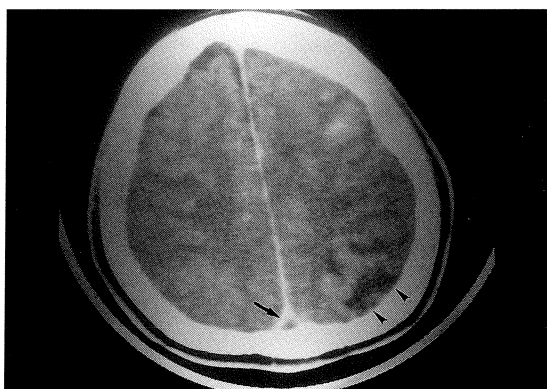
CT scan of the brain. The 'empty delta sign' seen following contrast enhancement due to a clot (the filling defect) within the sinus with contrast outlining it (arrow). Note the venous infarct in the left parietal lobe posteriorly (arrowheads).
